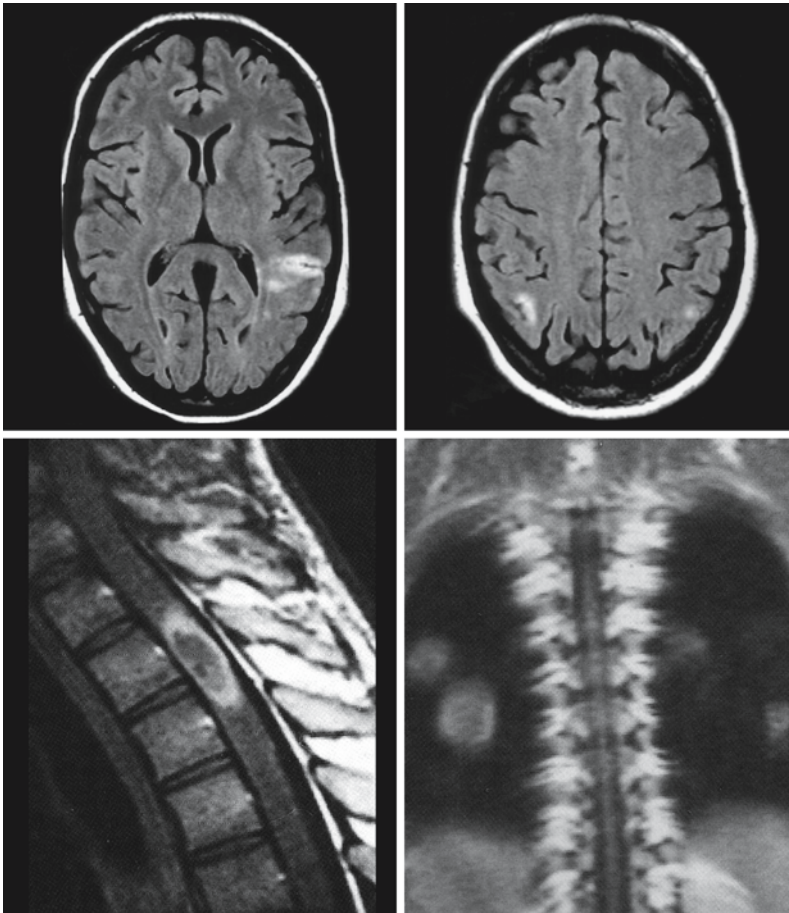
A 9-year-old boy with Wegener disease. The FLAIR images through the brain show subcortical and cortical spots with hyperintensity. In the thoracic spinal cord there is an intramedullary lesion with ring enhancement and lower signal intensity in the core of the lesion. In the lungs there are multiple granulomas
